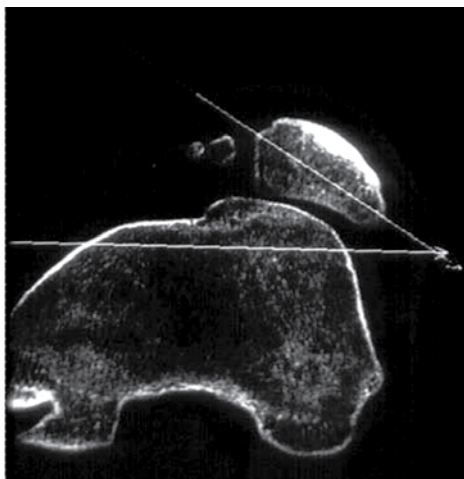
Patellar Tilt (CT).
